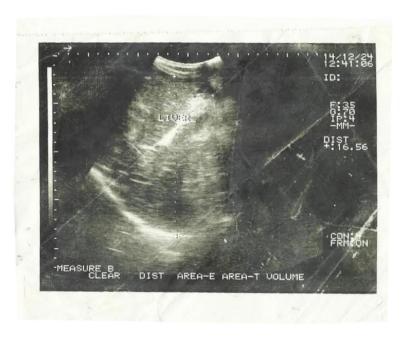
B: Ultrasound of Same above patient showed thickened edeamatous GB wall (16mm)
